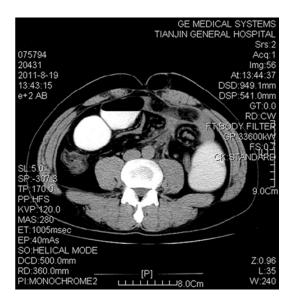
Emergency Plain abdominal CT scan on day 10 Post-operation showed the features of acute bowel obstruction with dilated bowel loops and increased density of mesentery, may be previous surgical area? (White arrow).
